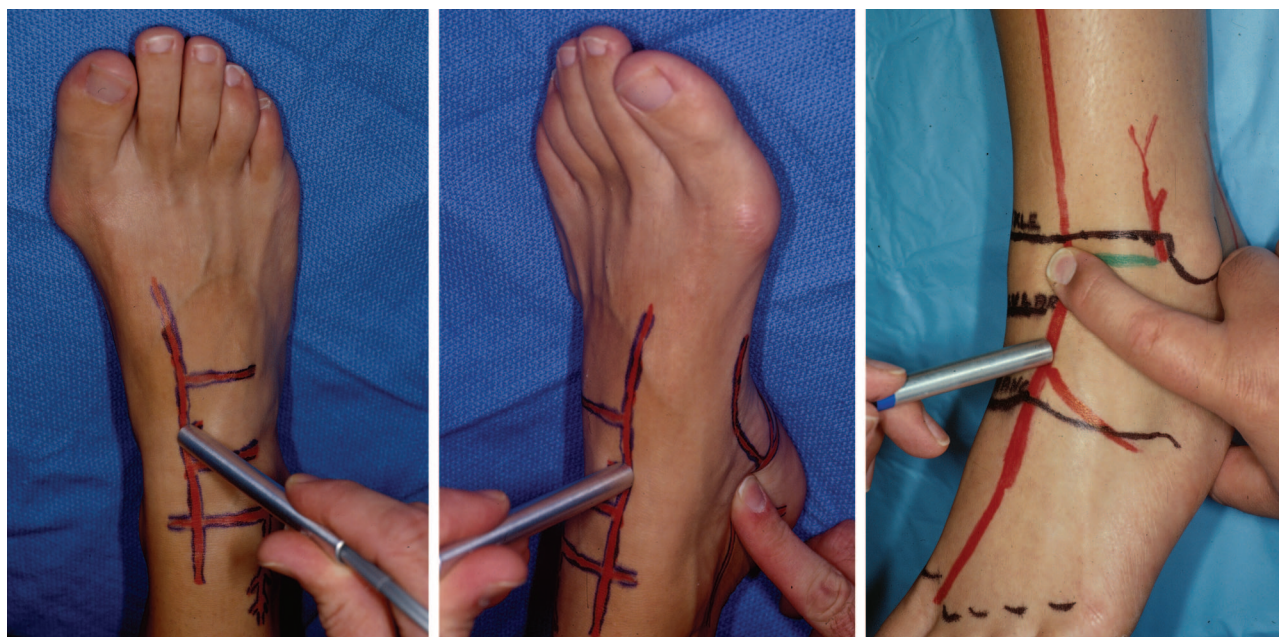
(Left) The dorsalis pedis is followed using Doppler imaging proximal to Lisfranc's joint. (Center) If, when pressure is applied to the posterior tibial artery at the tarsal tunnel, the Doppler sound continues, then there is antegrade flow. If the Doppler sound disappears, then the flow to the dorsalis pedis artery is retrograde from the posterior tibial artery via the lateral plantar artery. (Right) This is confirmed by occluding the anterior tibial artery at the takeoff of the lateral malleolar artery and listening for retrograde flow from the posterior tibial artery.
